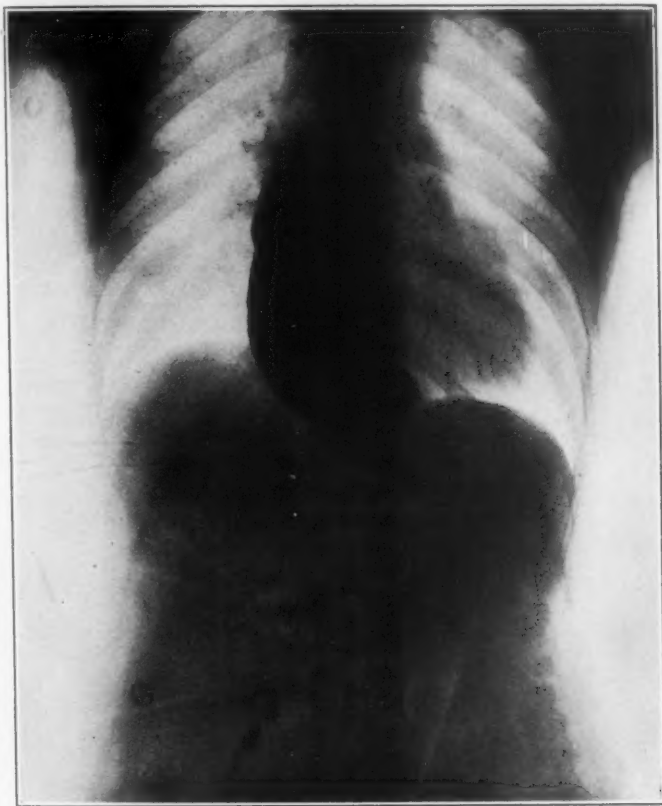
Radiograph (by Dr. George C. Johnston) of a woman of 45 years, showing an abdominal esophagismus which was afterward cured by endoscopic mechanical division. The "flat floor" of the dilatation shows why previously used blind methods had failed to introduce any instrument through the hiatus. The possibility of the radiograph being taken just before normal physiologic opening of the cardia in the deglutitory cycle was eliminated by the elapsed time.
